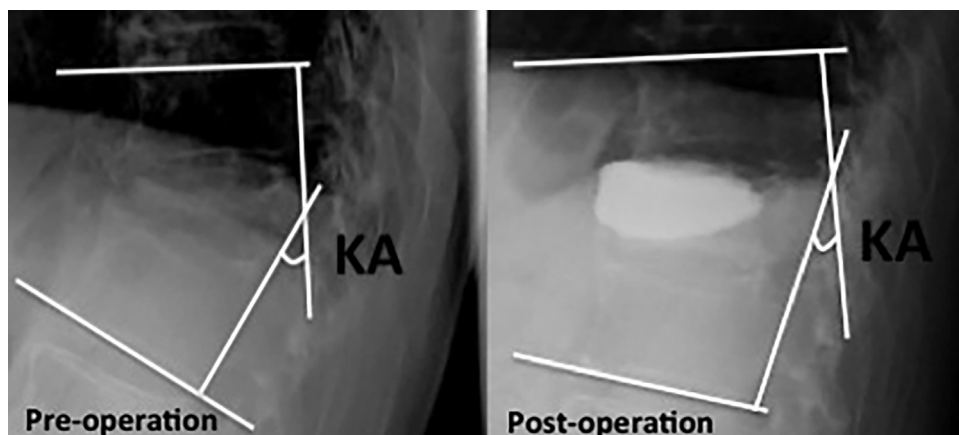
X-ray films showing the method by which the focal kyphosis angle was measured. The focal kyphosis angle between the higher end plate of the upper vertebral body and the lower end plate of the lower vertebral body was measured.
